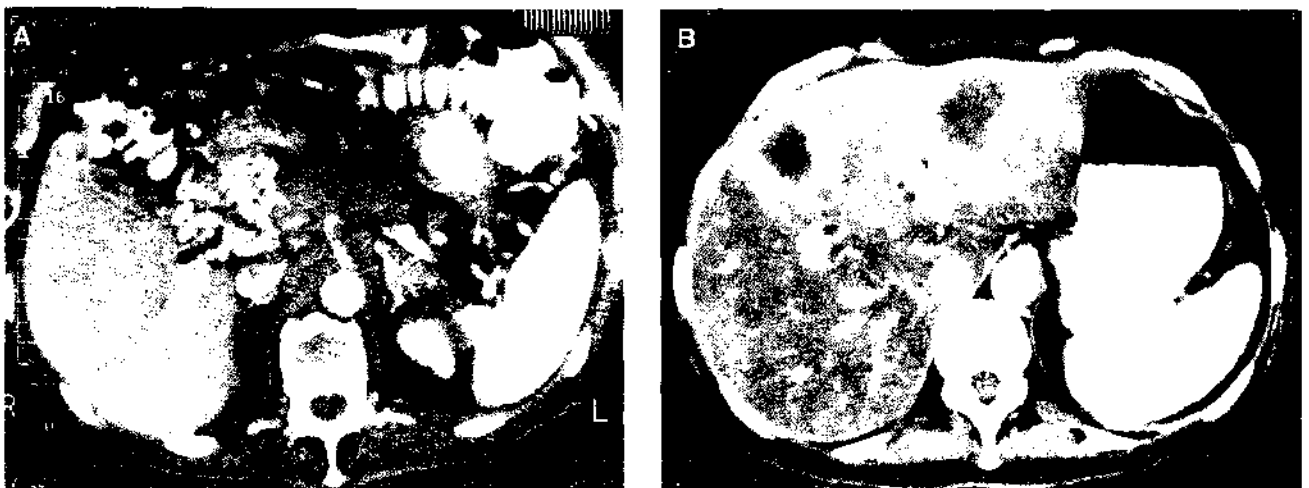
(A) CT scan of an unresectable adenocarcinoma of the pancreatic head with tumor encasement of the celiac artery. Note the extensive venous collateral secondary to occlusion of the superior mesenteric–portal vein confluence. (B) Large hypodense liver metastases in stage IV pancreatic adenocarcinoma.
